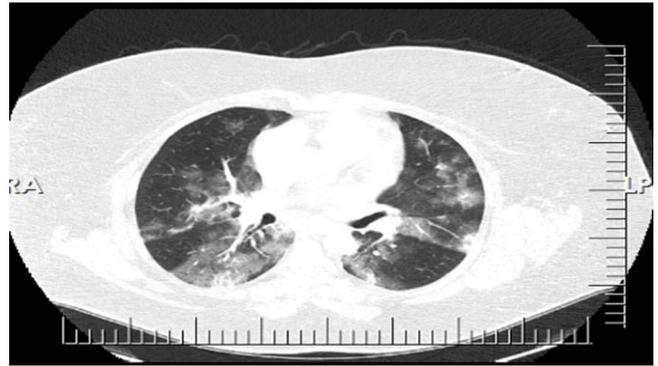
The patient's Computed Tomography image
